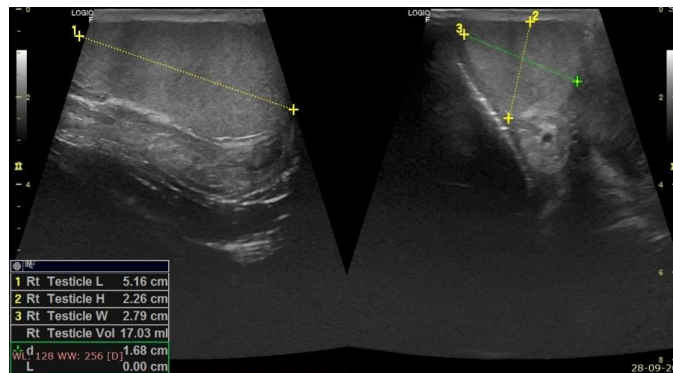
Ultrasound image of right testis. Horizontal and transverse section show normal echogenicity and volume.
